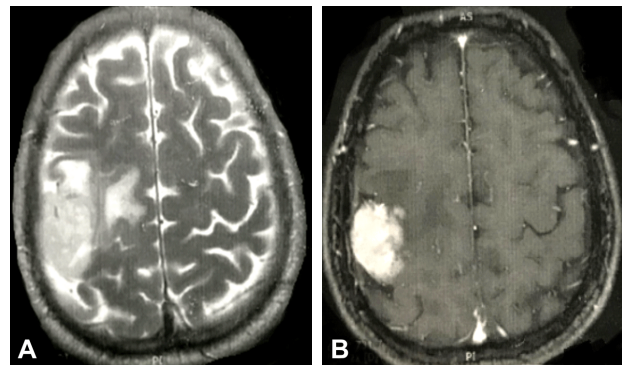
Radiographic features of GB in Case No. 2. Axial brain MRI (January 2018) identified a solid, expansive, heterogeneous lesion, located in the right fronto-parietal area, that seems to develop on the external surface of the brain, with minimal infiltration in the adjacent nervous tissue: (A) T2 sequence showing apparently an extra-axial solid mass with moderate peripheral edema; (B) T1 post-contrast image showing important gadolinium enhancement of the tumor. GB: Glioblastoma; MRI: Magnetic resonance imaging.
